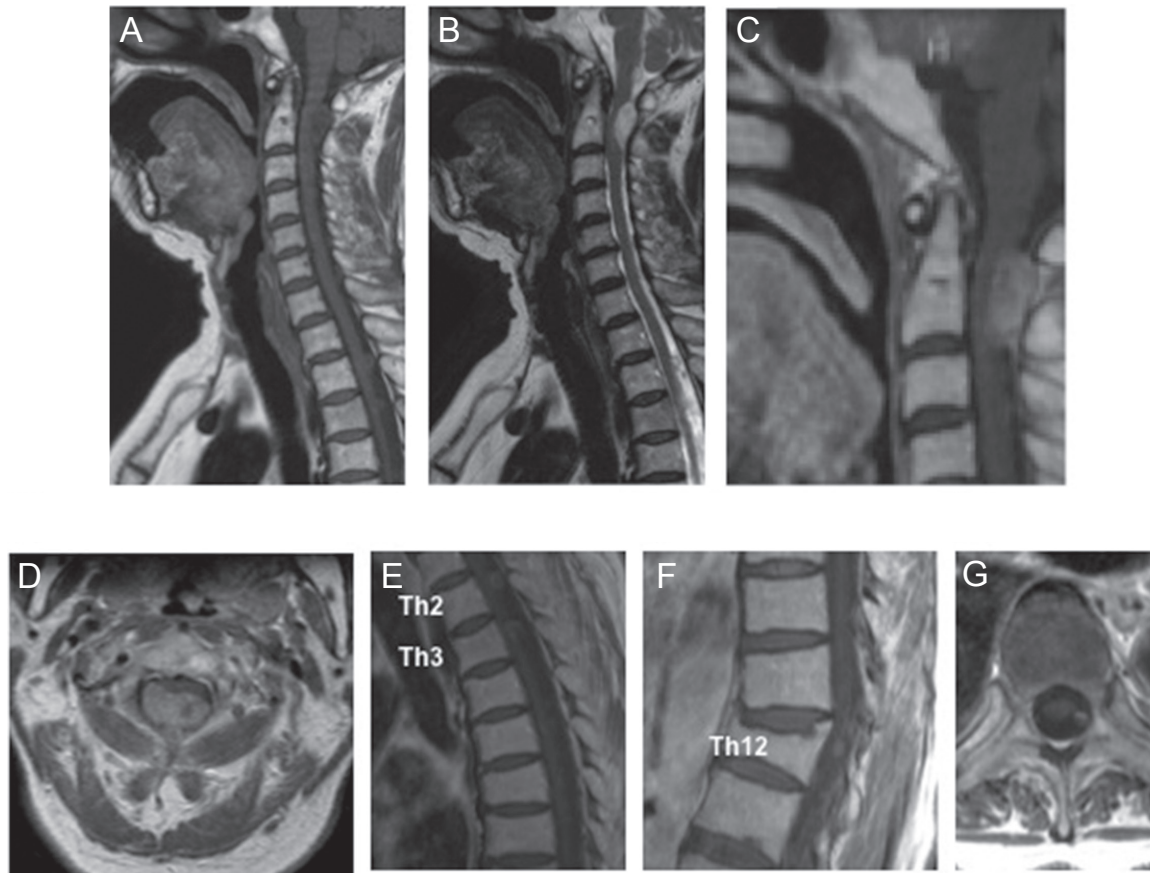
A: Preoperative T₁-weighted sagittal magnetic resonance imaging (MRI) shows an isointense lesion at C1/C2 level. B: Preoperative T₂-weighted sagittal MRI shows a hyperintense lesion at C1/C2 level. C: Preoperative T₁-weighted sagittal MRI with gadolinium reveals homogenous enhancement of the lesion. D: Preoperative T₁-weighted axial MRI with gadolinium demonstrates an intradural extramedullary lesion that displaced the spinal cord anteriorly. E: T₁-weighted sagittal MRI shows isointense lesions at Th2 and Th3 levels. F: T₁-weighted sagittal MRI shows an isointense lesion at Th12 level. G: T₁-weighted axial MRI demonstrates an intradural extramedullary lesion at Th2 level.
